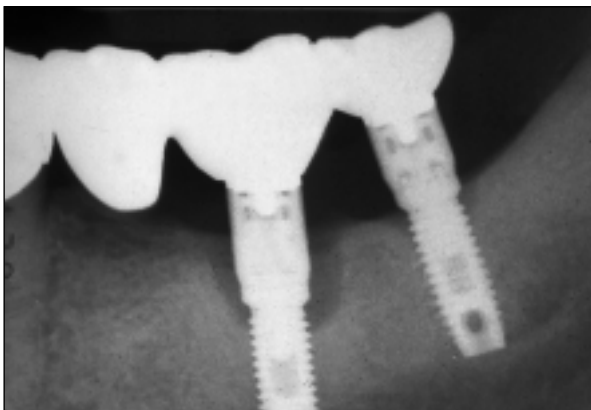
(Above) Radiographic "cupping" of the bone preceding implant fracture.
